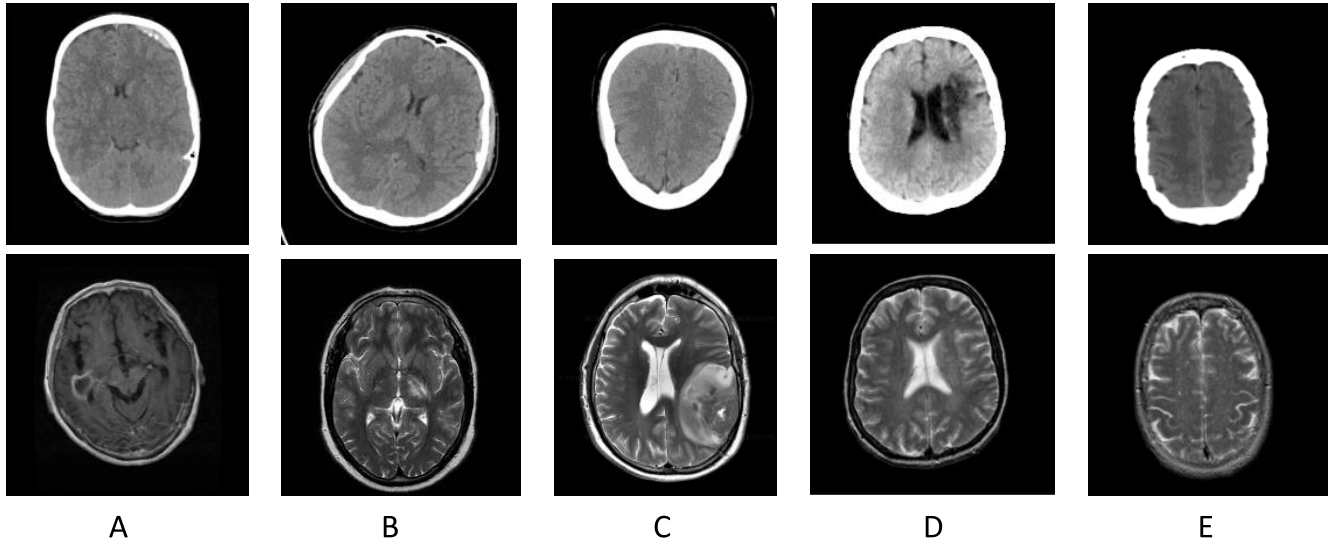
Five sets of preprocessed data were randomly selected from the two datasets. The images displayed in A, B, and C are unpaired CT and MR images selected from the Kaggle [64] dataset. The images displayed in D and E are paired CT and MR images selected from the [41] and [59] dataset. All the displayed images are denoised head medical images.
